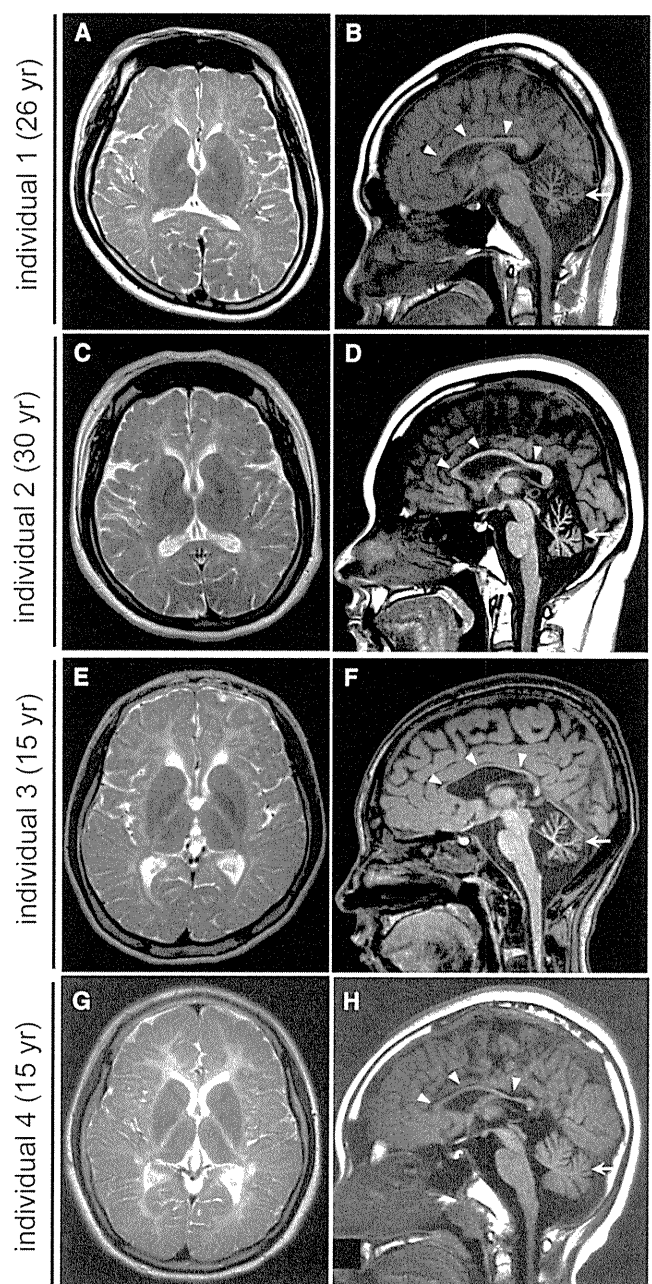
Brain MRI of Individuals with *POLR3B* and *POLR3A* Mutations
